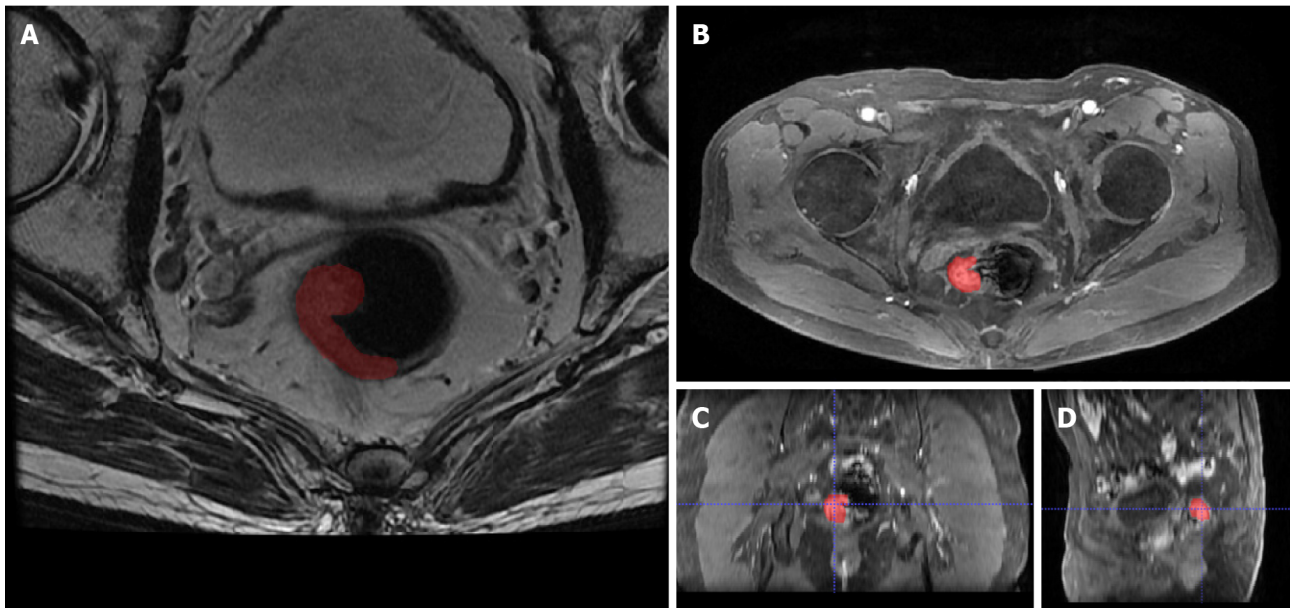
Segmentation of a rectal tumor with Itk-snap software. A: Example of tumor segmentation using Itk-snap software (www.itksnap.org) on axial plain magnetic resonance image; B-D: Axial (B), reconstructed coronal (C), and sagittal (D) contrast-enhanced magnetic resonance images in the venous phase in a 72-year-old man with rectal cancer.
